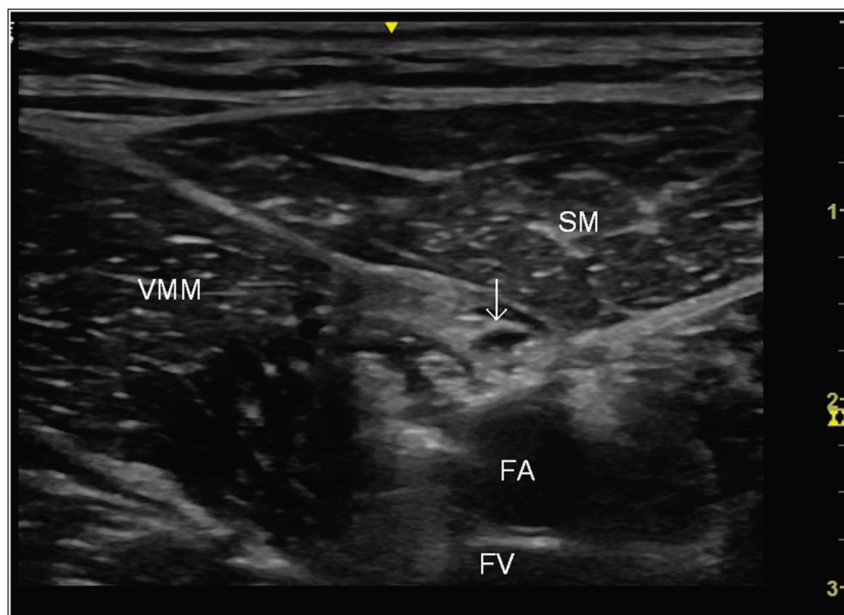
Ultrasound image after injection of local anesthetics into the adductor canal at the midhigh level. White arrow, saphenous nerve; SM, sartorius muscle; VMM, vastus medialis muscle; FA, femoral artery; FV, femoral vein.
